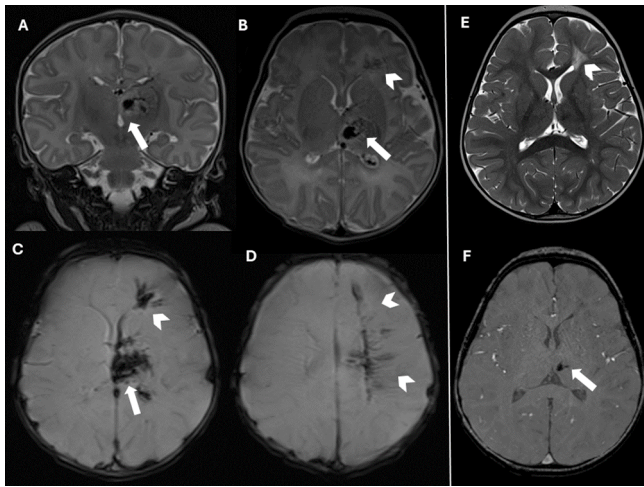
A. Coronal T2 Weighted Images, B. Axial T2 Weighted Images, C. and D. Axial T2 Gradient Echo Weighted Images showing a left thalamic venous infarction (arrows) and homolateral extensive thrombosis of the deep medullary with punctate and linear lesions (arrowhead). E. Axial T2 Weighted Images and F. Axial Susceptibility Weighted Imaging (SWI) follow-up MRI at 18 month of life showing a glio-malacic evolution of the periventricular white matter lesions (E, arrowhead) and punctate hemosiderin deposits in the left thalamus (arrow F).
